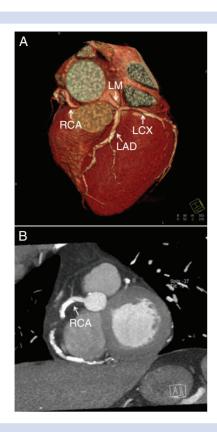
Multiple calcified plaques present on the coronary arteries of a liver transplant recipient, as shown by coronary computed tomographic angiography (A: short-axis view; B: volume-rendered image). The total coronary calcium score is 2601 in this patient [right coronary artery (RCA): 1611; left anterior descending coronary artery (LAD): 746; left circumflex coronary artery (LCX): 228; left main coronary artery (LM): 16].
